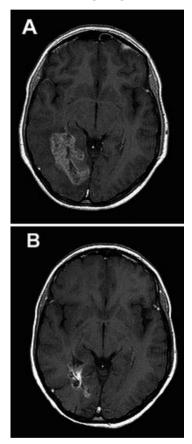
Transverse magnetic resonance imaging (MRI) brain scans revealed the tumor mass in right parietal-occipital region in the 18year-old woman with glioblastoma multiforme. A. Largest size of tumor mass at baseline, 5.9 × 2.9 cm. B. Largest size of tumor mass after 20 cycles of chemotherapy with edotecarin, 3.8 × 1.5 cm.
